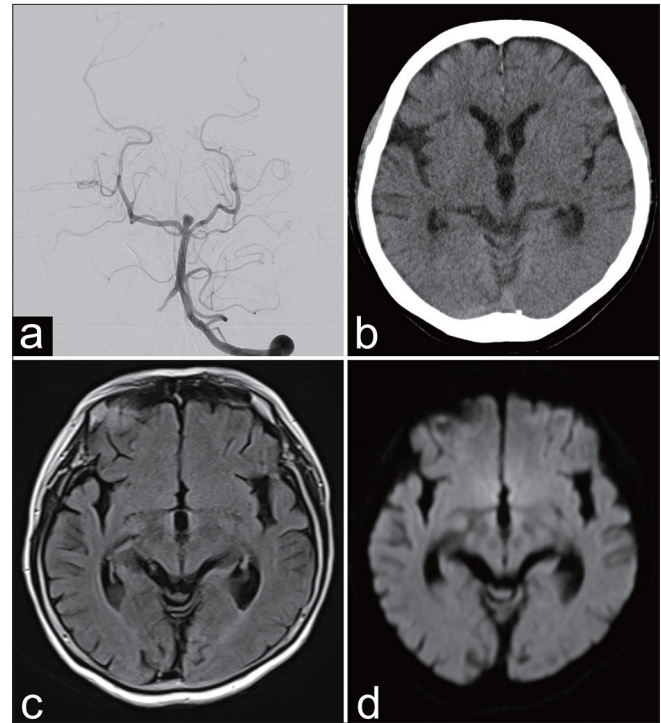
(a) Left vertebral angiography shows a 2.7×5.6 mm basilar artery aneurysm. (b) Computed tomography 4 h post-angiography reveals no hyperdense areas in the posterior hemisphere. (c) Fluid-attenuated inversion recovery imaging scan shows no hyperintense regions. (d) Diffusion-weighted imaging scan shows no hyperintense regions.
